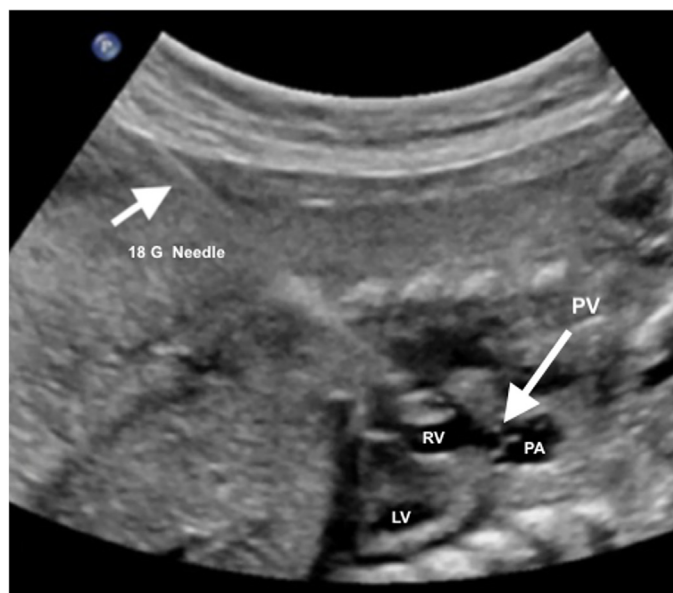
Ultrasound image showing an 18-G needle passing through the maternal abdomen, uterus, fetal anterior chest wall, and right ventricle (24). LV: Left ventricle, PA: Pulmonary artery, PV: Pulmonary valve, RV: Right ventricular, 18-G: 18-Gauge
